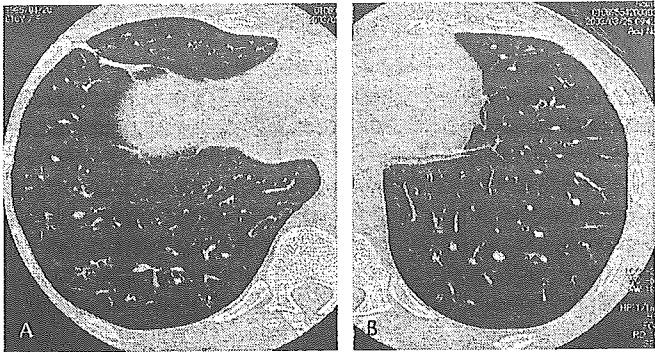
HRCT scan (1 mm collimation with high-resolution algorithm after the therapy demonstrates improved dilated thick-walled bronchioli and the centrilobular linear and branching opacities.
